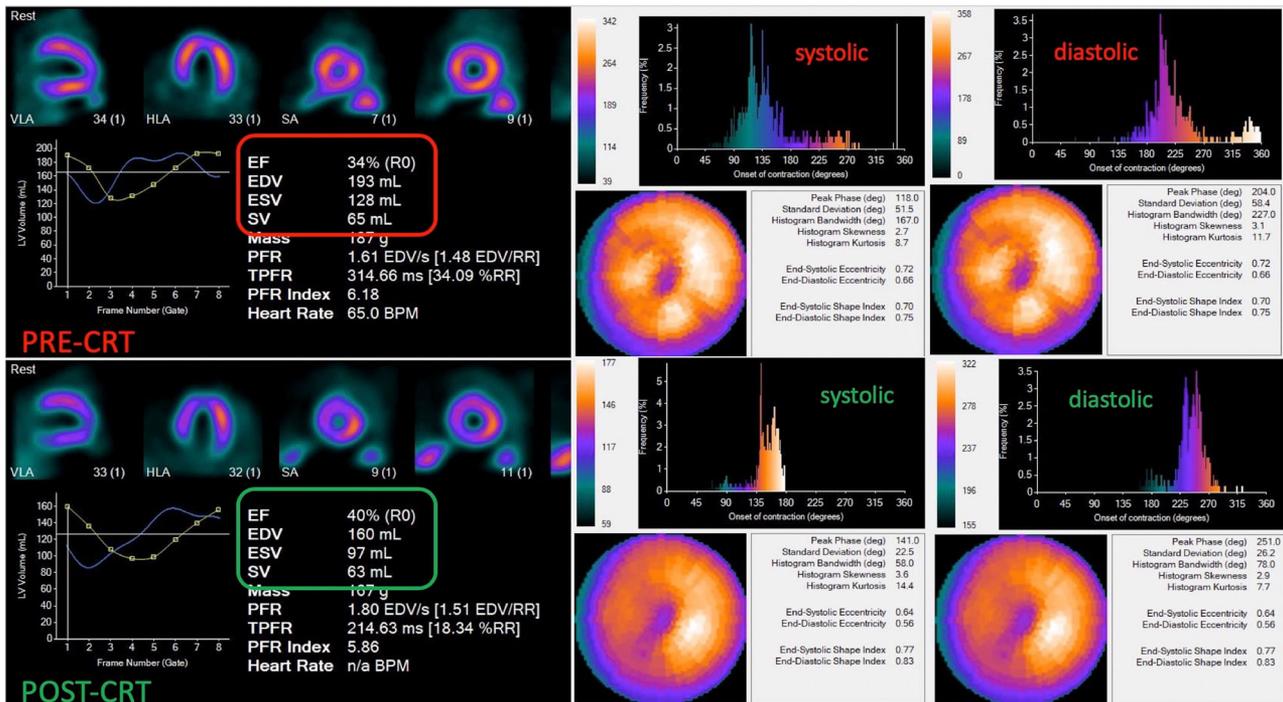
This is an example of the automatized analysis made with 99mTc-MIBI SPECT and reported no evidence of infarction or ischemia, LVEF-34%, LVEDV-193 mL, LVESV-128 mL, diastolic standard deviation-58.4°. San Jude cardiac resynchronizer was placed in DDD mode. At follow-up, the patient improved LVEF to 40%, LVEDV decreased to 160 mL, LVESV decreased to 97 mL, and diastolic standard deviation improved to 26.2°.
